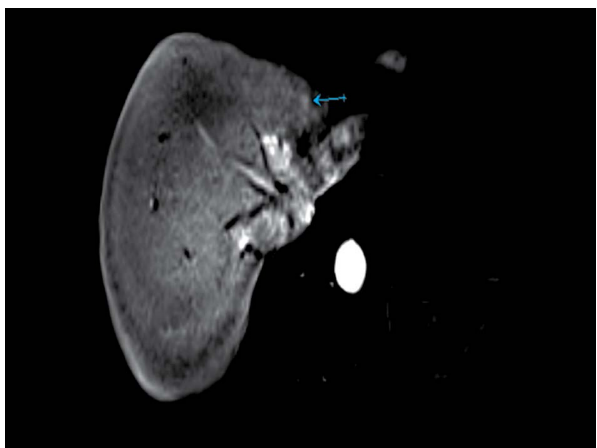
MR image of the FNH of the segment II of the liver, an axial image in the arterial phase of the scan
